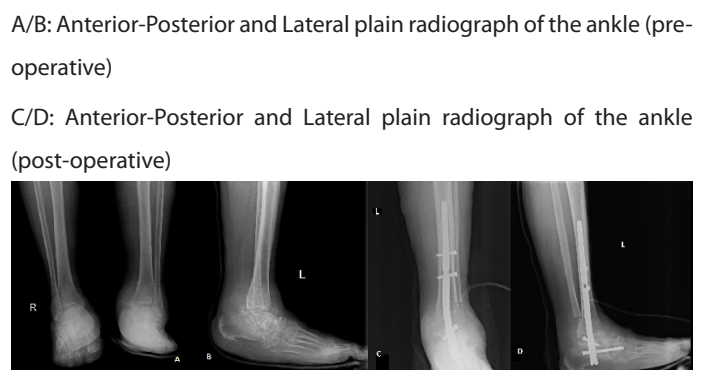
Pre-operative and post-operative plain radiographs of Patient 4. A/B: Anterior-Posterior and Lateral plain radiograph of the ankle (pre-operative) C/D: Anterior-Posterior and Lateral plain radiograph of the ankle (post-operative)
